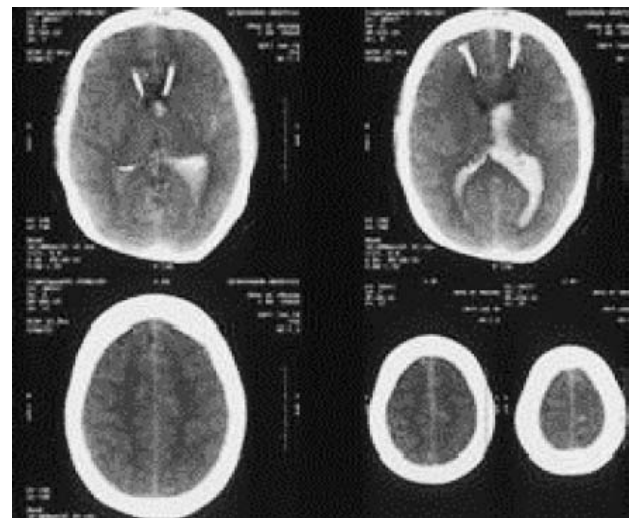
CT image of brain scans of the same patient taken 4 days after external ventricular drainage performed via bilateral rapid pore cranial drilling. The results showed absence of hydrocephalus and reduced hemorrhage in the ventricles.
